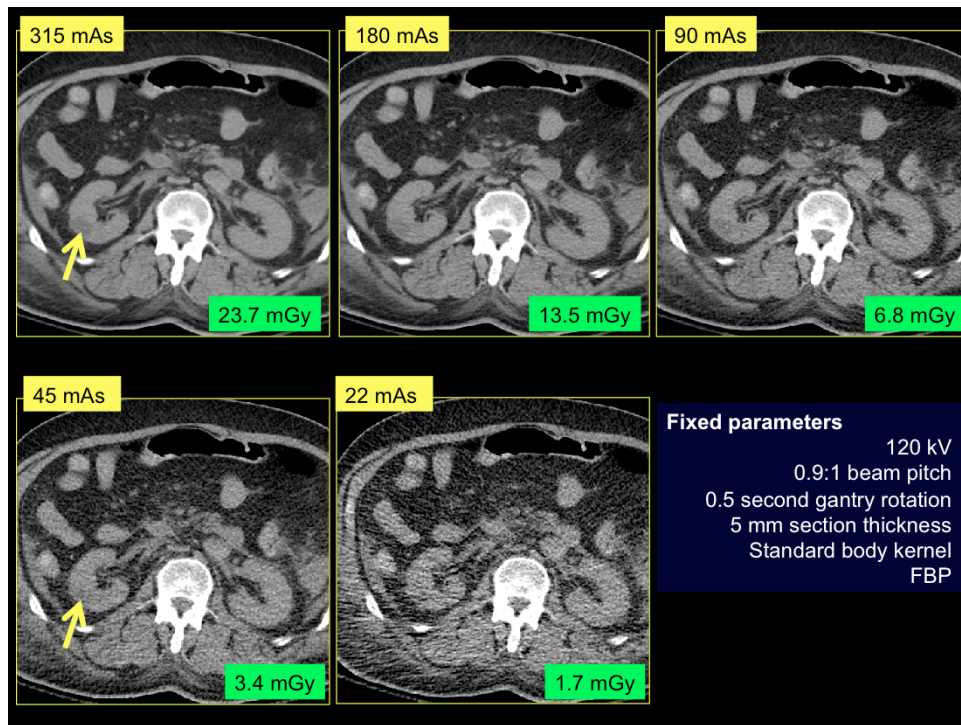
Post mortem abdominal CT images of a 60 year old male (82 kg) at various tube currents. Image noise increases as the tube current is lowered and interferes with the visibility of right renal low attenuation lesion (arrow). His autopsy report confirmed presence of cysts in the mid and lower pole of the right kidney.
